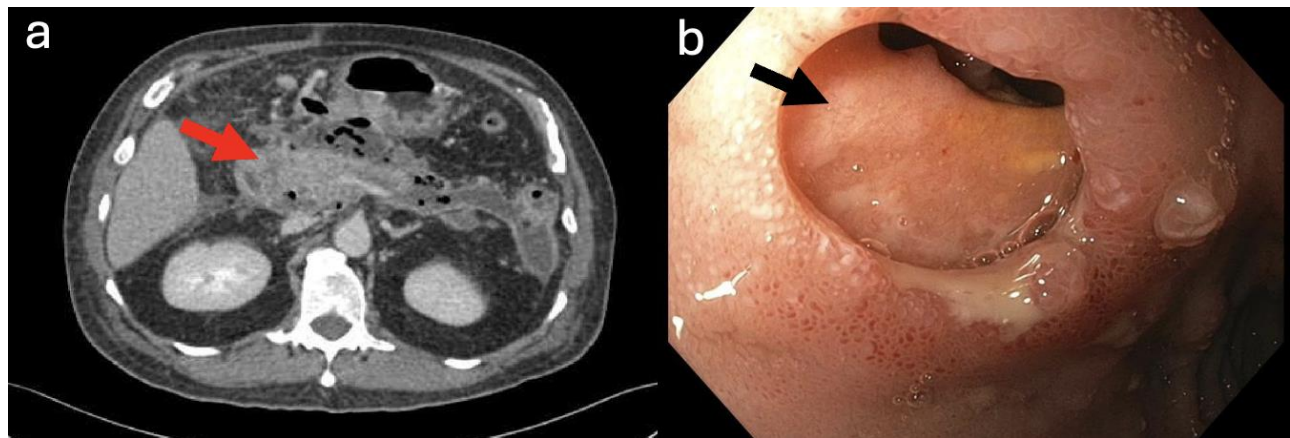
(a) Whole abdominal CT scan showed homogeneous enhancement of the pancreas, with fluid collections in the peripancreatic, left anterior peritoneum, mesentery, perigastric, perisplenic, left anterior pararenal space, and pelvic regions. The largest collection in the left anterior peritoneum, measures 9 x 47 mm (previously 21 x 82 mm, APxT). (b) Esophagogastroduodenoscopy showed that the first portion of the duodenum had an opening, approximately 2cm in size with purulent discharge and a visualized tract with surrounding erythematous mucosa with a few clean-based ulcers.
